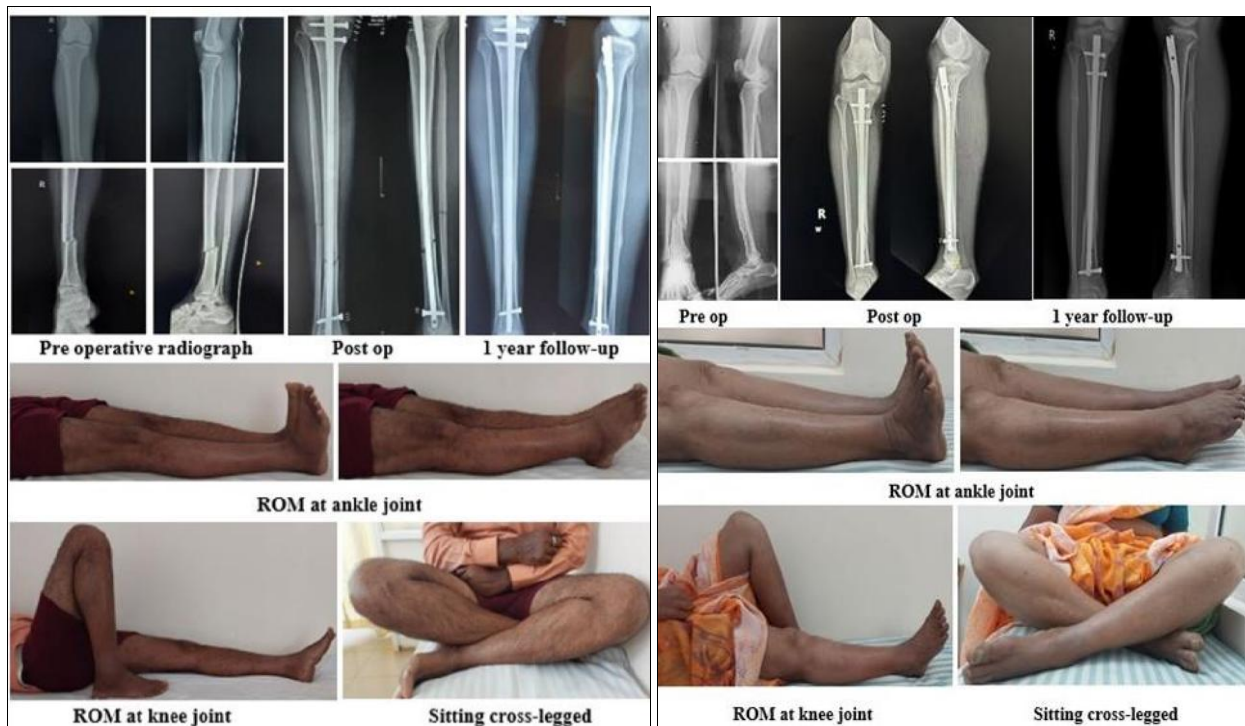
Radiographs and Clinical images. (SP approach) and (IP approach)
